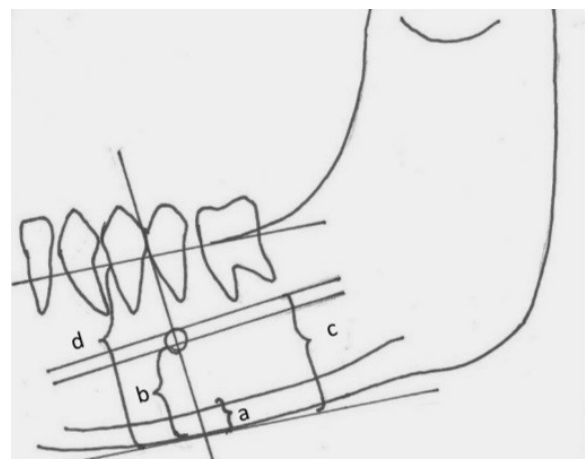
Measurements on the panoramic radiography. cw:a. PMI:a/b. M/M:d/c.
